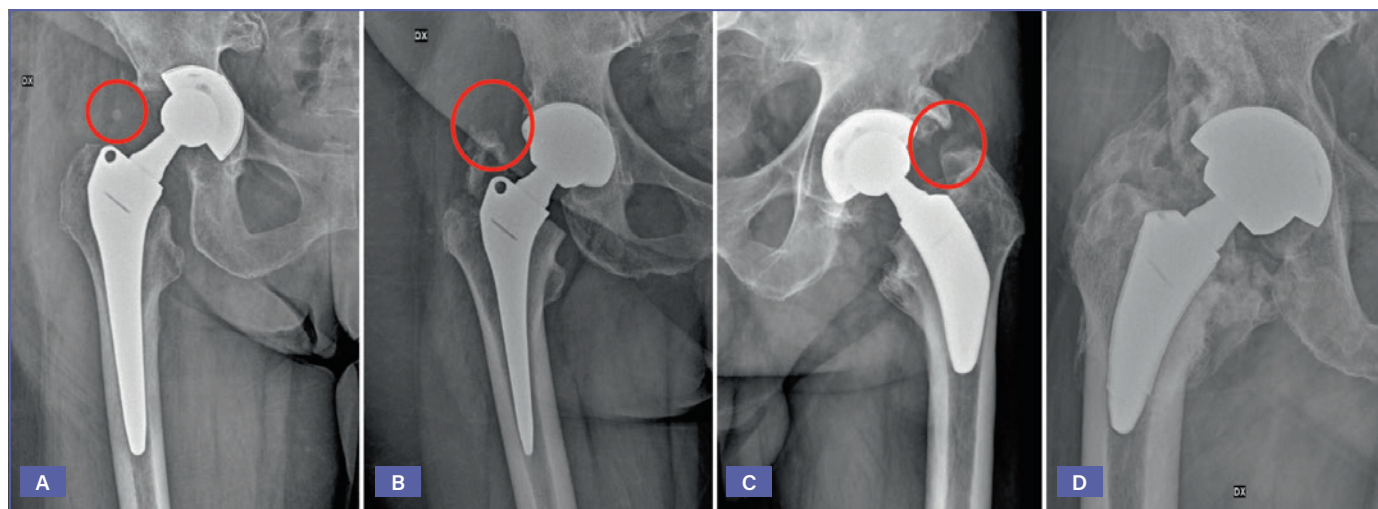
Brooker Classification of heterotopic ossifications (HO). A) Grade I: presence of an “island” of bone within soft tissue around the hip (red circle); B-C) Grade II-III: presence of bone spurs (red circles) on the proximal femur or pelvis with, respectively, > 1 cm (B) < 1 cm; D) between bone surfaces; D) Grade IV: a “bridging” ossification determining a radiographic ankylosis of the hip.
